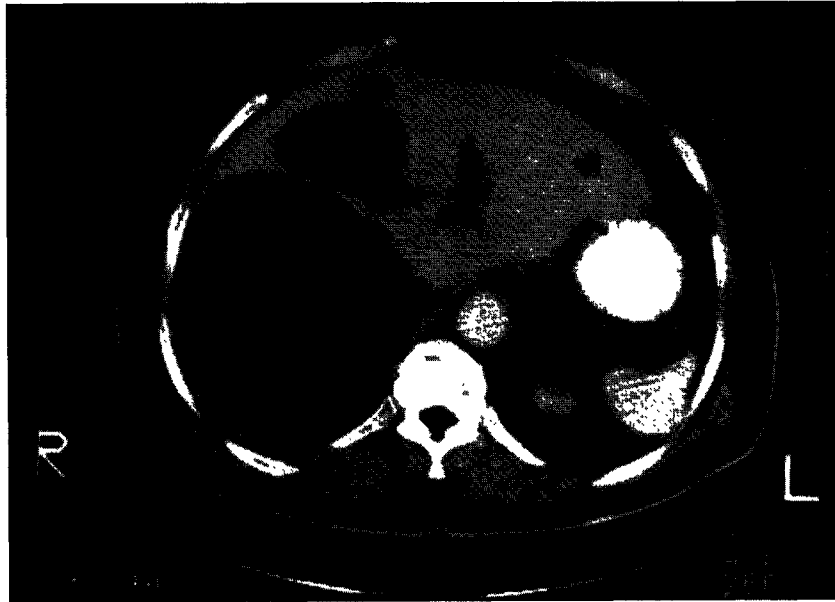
CT showed giant liver cyst before treatment
